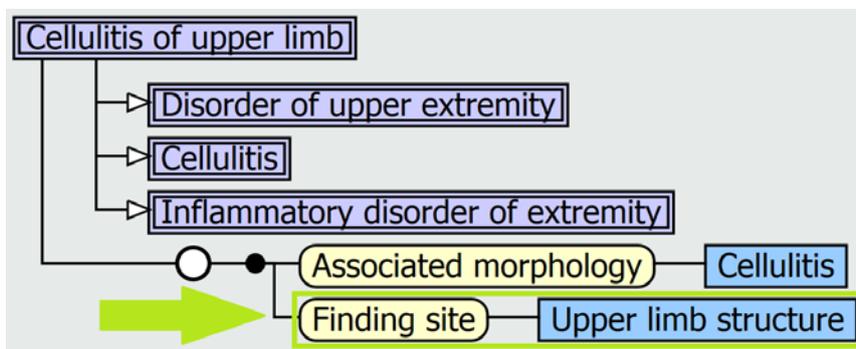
Use SNOMED CT-AU defining relationships to auto-populate data elements
